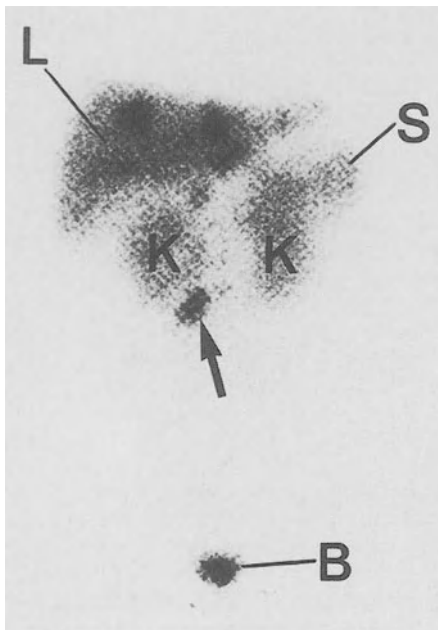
Multiple liver metastases in gastrinoma of the duodenum (*arrow*). Anterior view 4 h p.i.. Liver metastases had been missed by conventional ultrasonography, computed tomography, and magnetic resonance imaging. *L*, liver with multiple metastases; *S*, spleen; *K*, kidney; *B*, bladder
